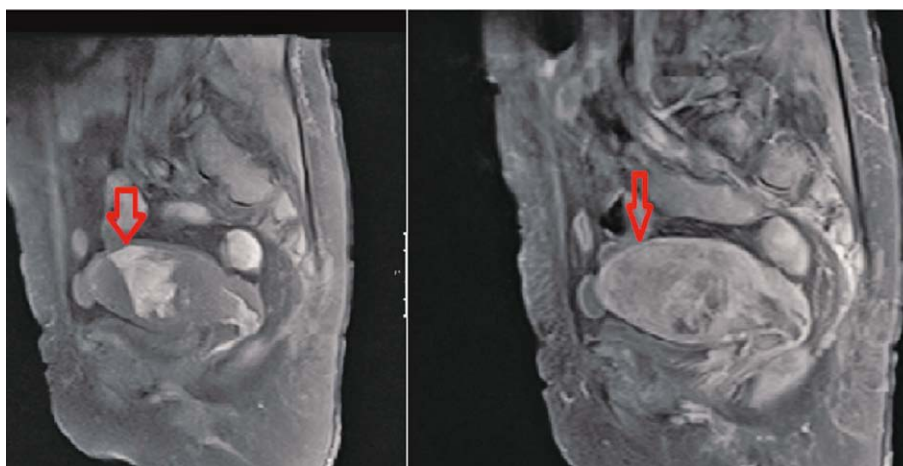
Myometrial invasion extending to serosa in the T2-weighted and T1 post-contrast sagittal sections of magnetic resonance image; red arrows indicate the depth of myometrial invasion.
